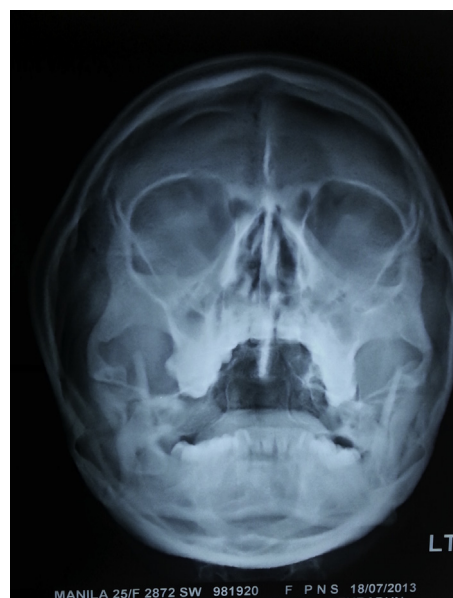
Sinus radiograph showing haziness in bilateral frontal and maxillary sinuses.
